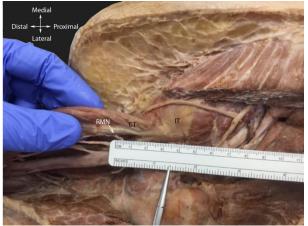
The recurrent motor nerve. Right gluteal and superior posterior thigh dissection. Lateral view. Demonstrating the distance between the origin of the conjoined tendon and the recurrent motor nerve's point of entry. RMN = recurrent motor nerve, CT = conjoined tendon of IhBF and ST, IT = ischial tuberosity.
